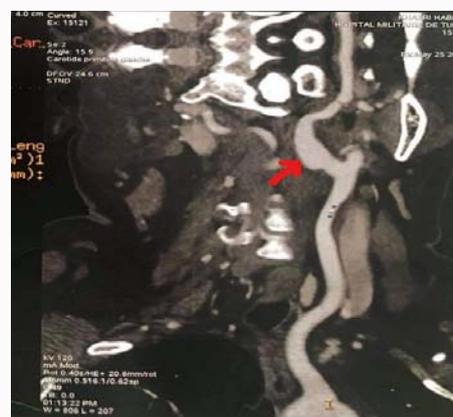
CT angiography showing the fusiform aneurysm of the ICA.
